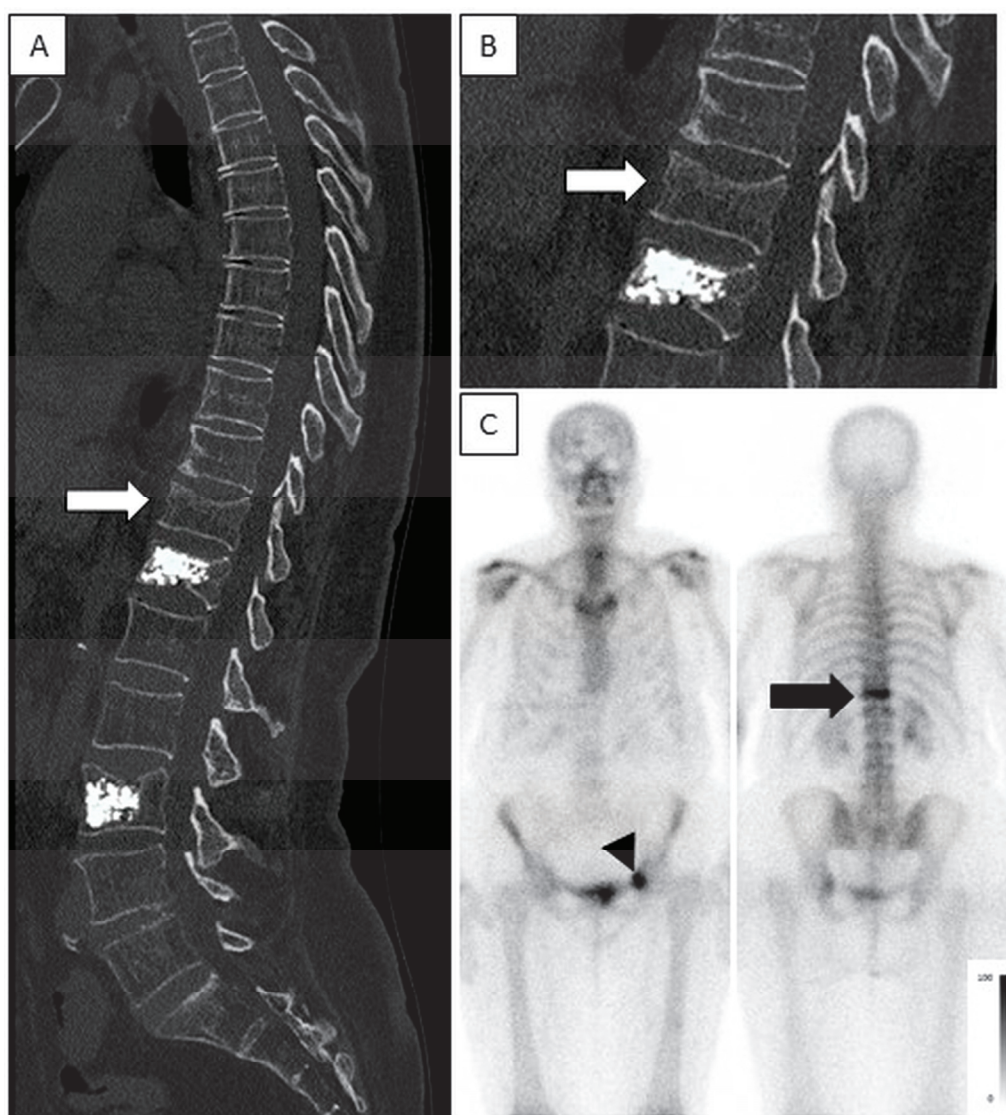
High-intensity uptake in an acute fracture, no uptake in chronic fractures post-vertebroplasty. A 77-year-old female after trauma. CT was acquired on the day of injury and bone scintigraphy was performed 3 days after the injury. (A,B)—Sagittal spine CT (enlarged in B) show an acute fracture in T11 (white arrow) and chronic fractures after vertebroplasty in T12 and L3. (C)—Planar anterior and posterior bone scintigraphy show high-intensity uptake in T11 (black arrow), indicating an acute fracture and no increased uptake in T12 and L3, consistent with chronic fractures. Note also, high-intensity uptake is seen in the anterior aspect of the left acetabulum (black arrow head), consistent with an acute fracture.
